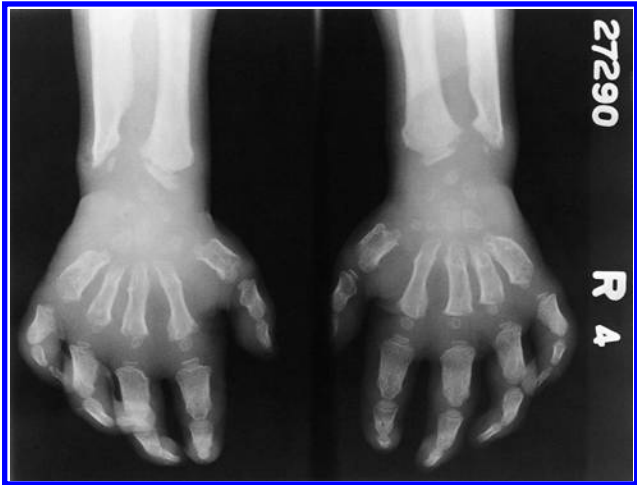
Roentgenogram of the hand of an 11-year-old patient with mucopolipidosis type III. The picture was that of an extreme degree of dysostosis multiplex.
